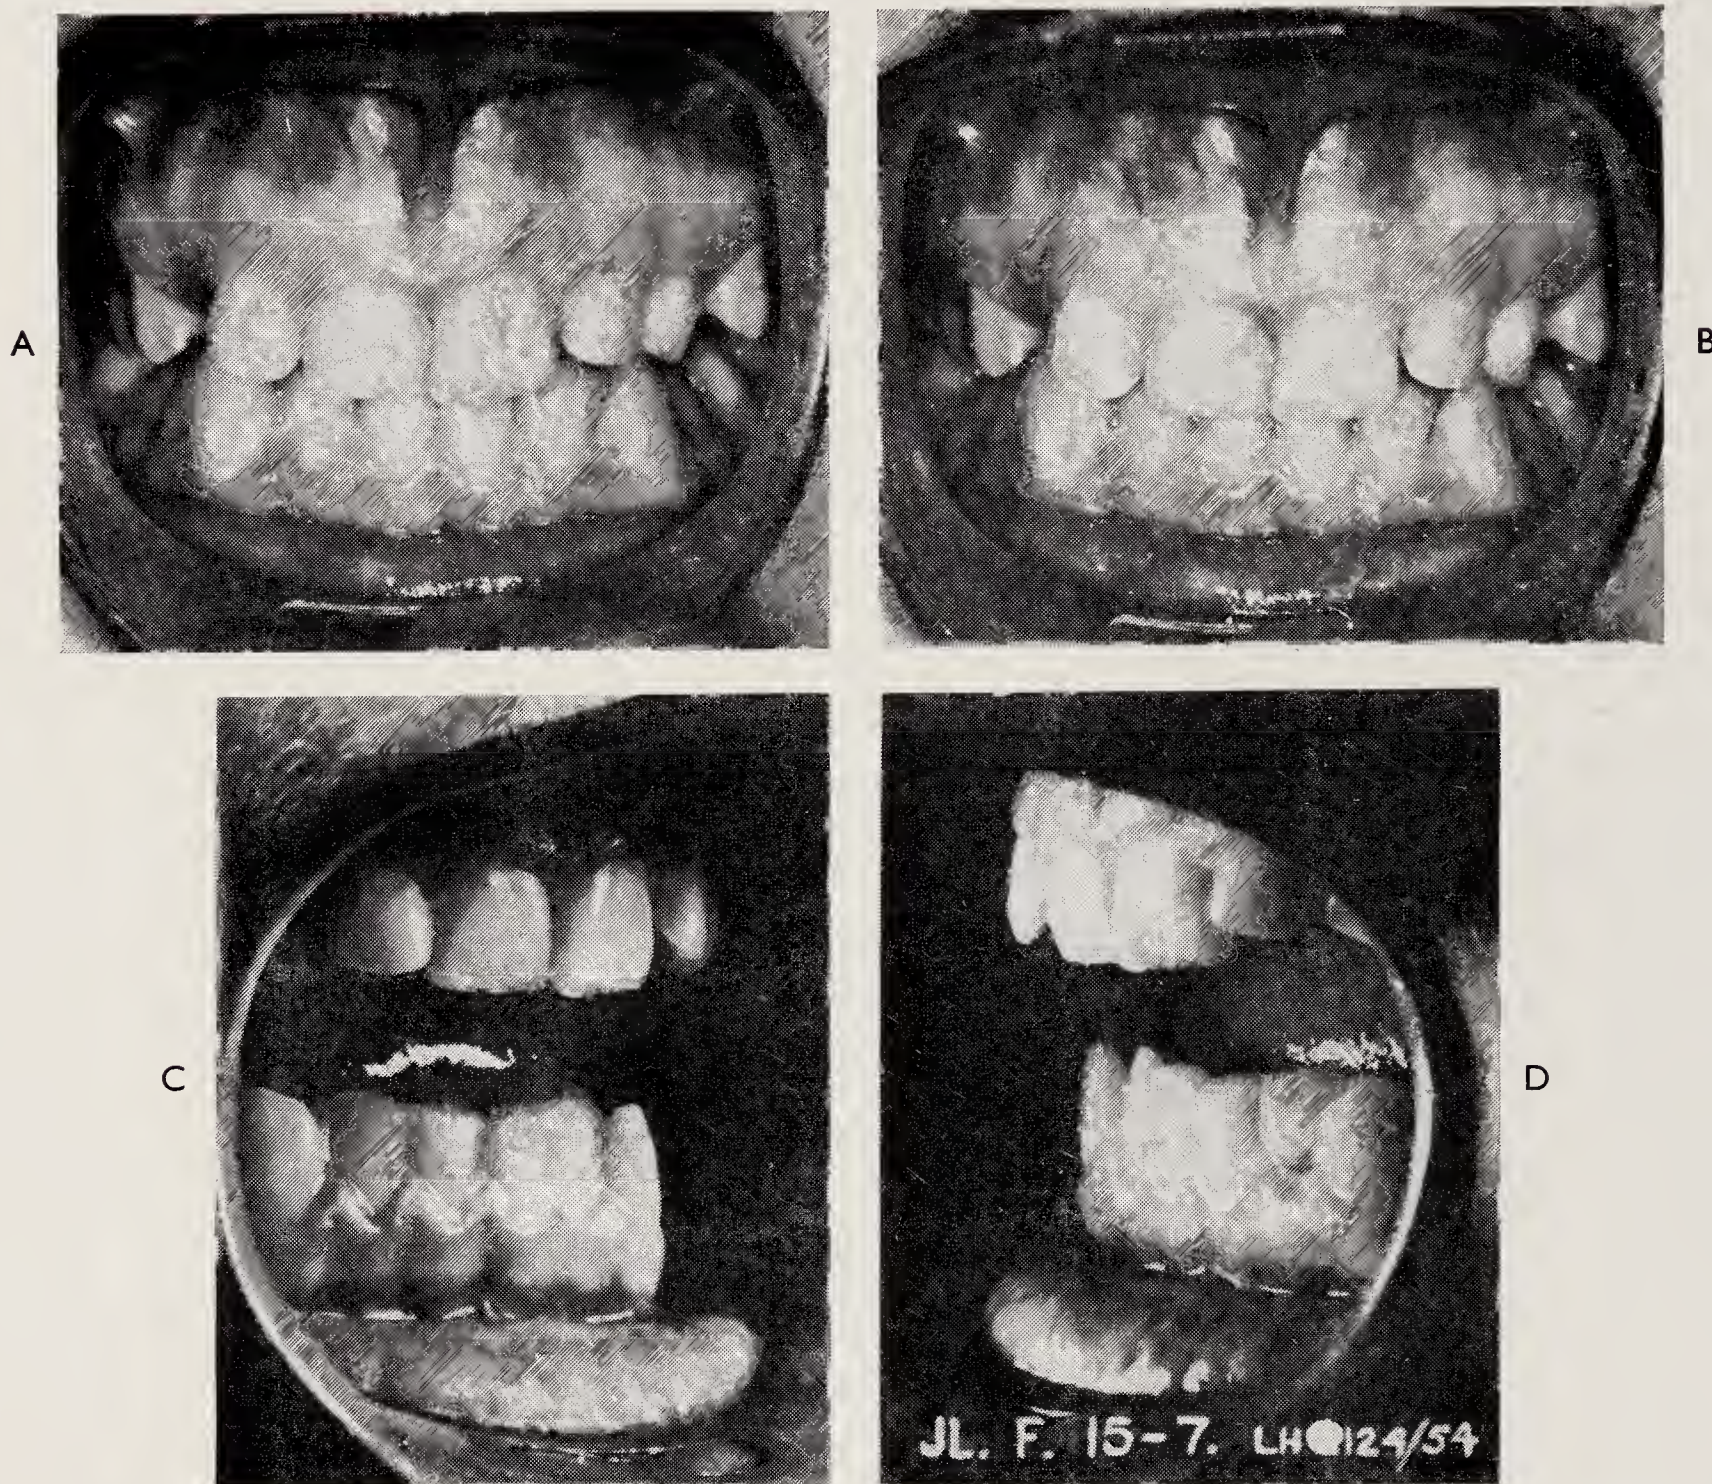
Showing teeth in initial contact (A) and in occlusion (B). The movement from one position to the other was sharp and quick. C, D show attrition on labial aspect of $\overline{I1}$. Radiographs confirmed distal displacement of the condyles following the backward displacement of the mandible.
